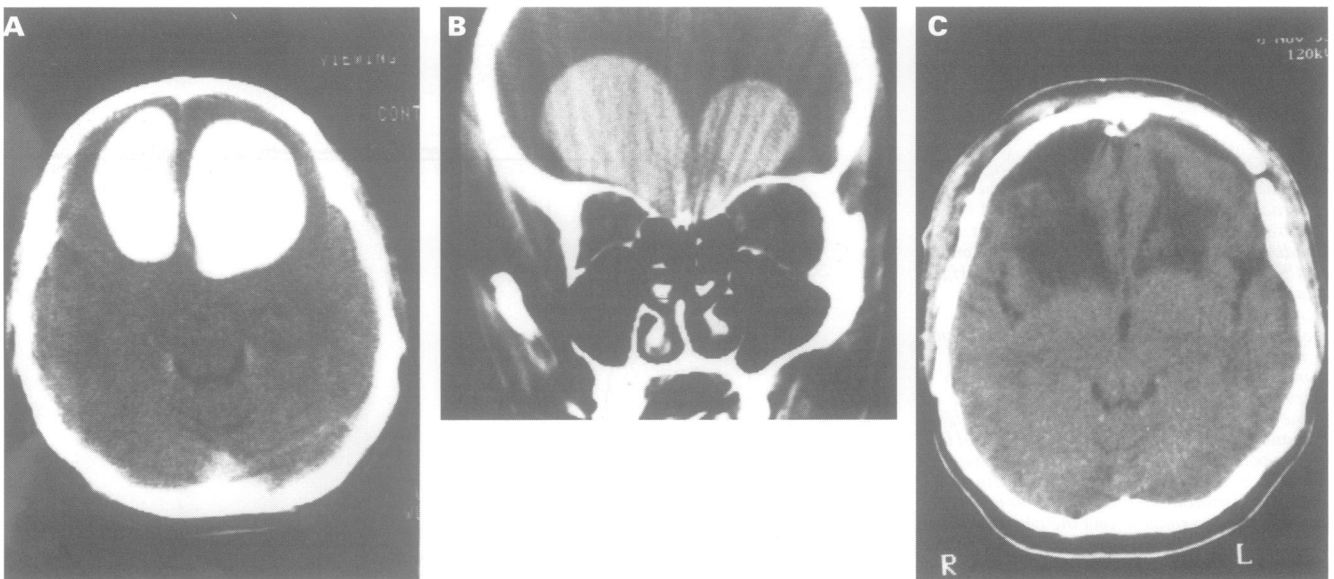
(A) Axial cranial CT (1989) showing the bilobed frontal hyperdense lesions. (B) Coronal cranial CT (1989) showing the communication of the lesions from the floor of the anterior cranial fossa. (C) Postoperative axial cranial CT (1993).
